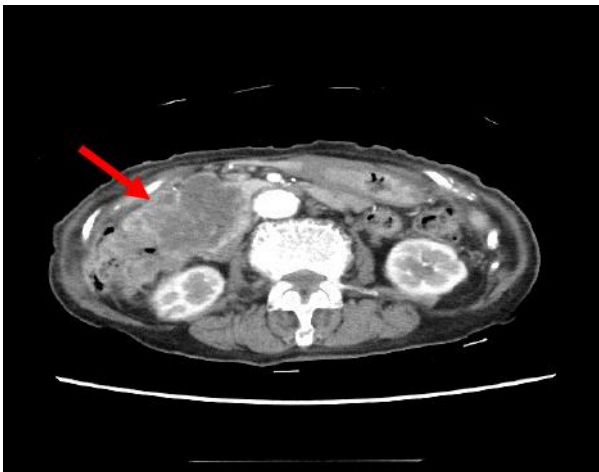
CT with intravenous contrast of the abdomen showing a duodenal tumor, multiple liver metastases, multiple lymphadenopathy, and ascites (arrow).
